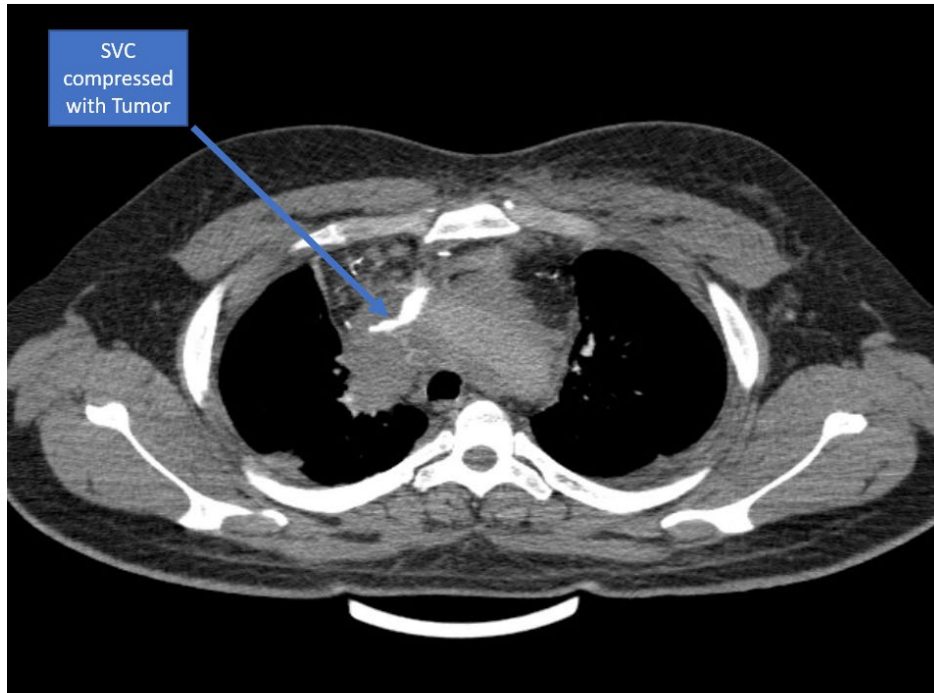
SVC compression with tumor, contrast enhanced CT scan
